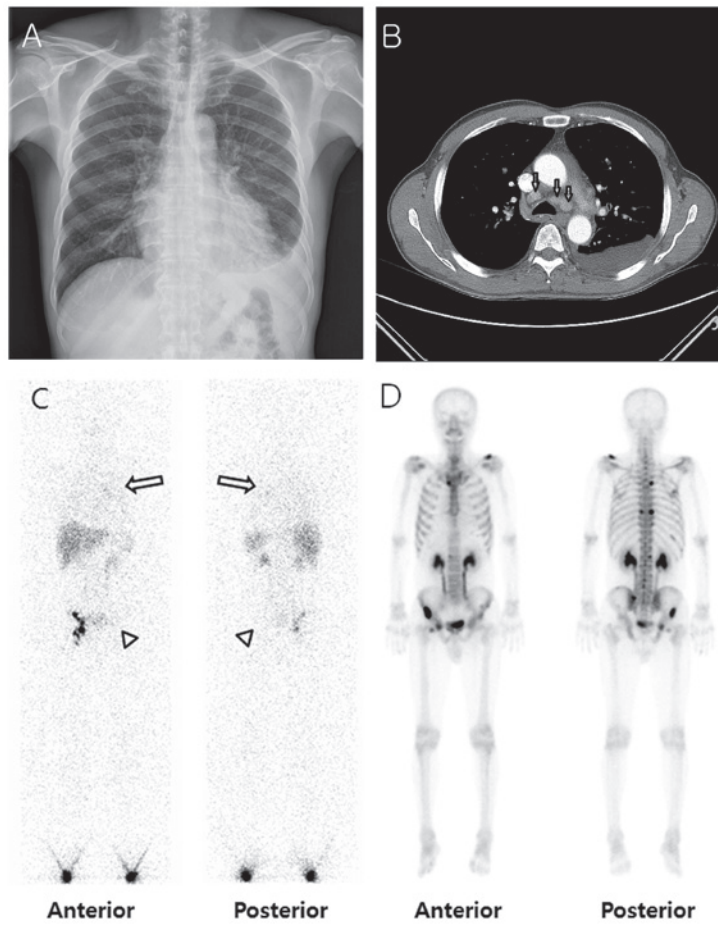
Chest radiography, chest computed tomography (CT), whole-body lymphoscintigraphy and bone scan images at diagnosis. (A) Chest radiography showing left pleural effusion. (B) Chest CT revealing mediastinal lymph node metastatic nodules (arrows) and left pleural effusion. (C) Whole-body lymphoscintigraphy image captured 2 h after radiotracer injection, revealing faint tracer accumulation activity in the medial portion of the left hemithorax, where pleural effusion was present (arrows). Tracer activity is absent in the left ilioinguinal chain (arrowheads). (D) Bone scan showing multiple bone metastases in the left clavicle, right ribs, thoracolumbar spine, bilateral pelvic bones and right femur.
